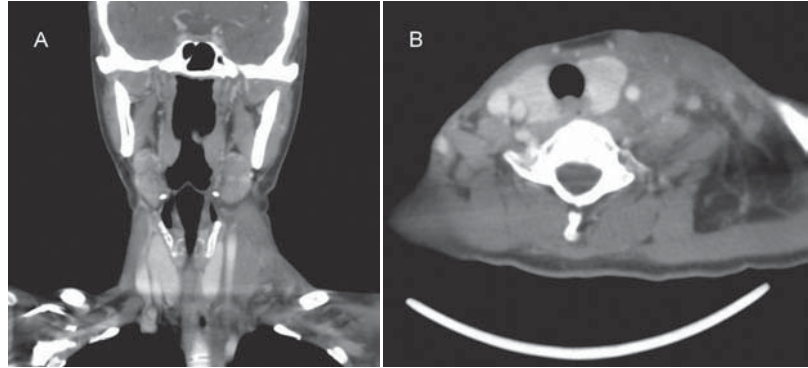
Contrast-enhanced computed tomography of the neck with coronal multiplanar reformation (A), axial view (B). There is a central low density (non-enhanced filling defect of the internal jugular vein) which indicating thrombophlebitis of the internal jugular vein (*Asterisk*) and marked swelling with fat stranding over the adjacent left neck. (*T*: thyroid tissue, *A*: the right internal carotid artery, *V*: the right internal jugular vein).
